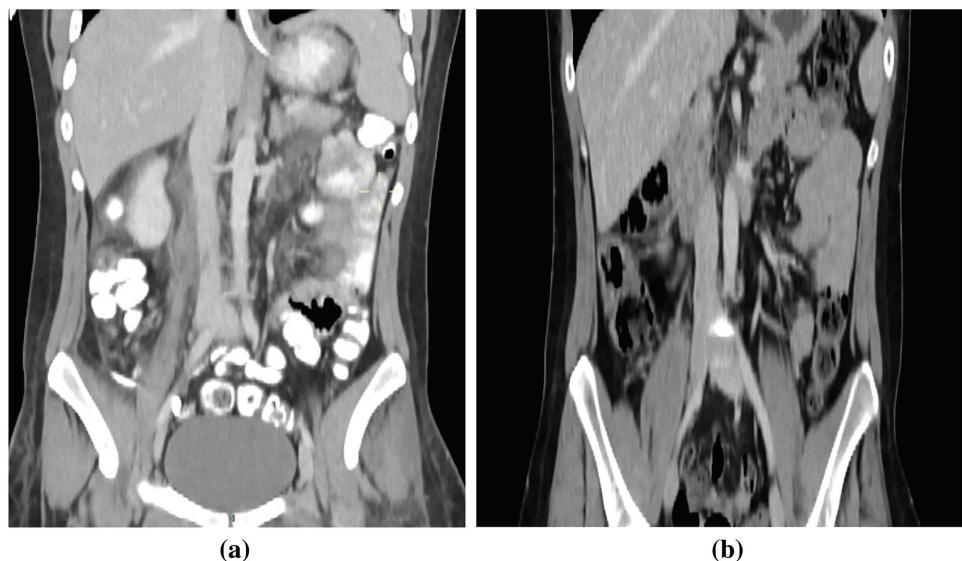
(a) Coronal CTA view with patent inferior vena cava (IVC) with local residual thrombus at the repair site, the patient received oral anticoagulation. (b) CTA 3 months later, patent IVC without residual thrombus.
